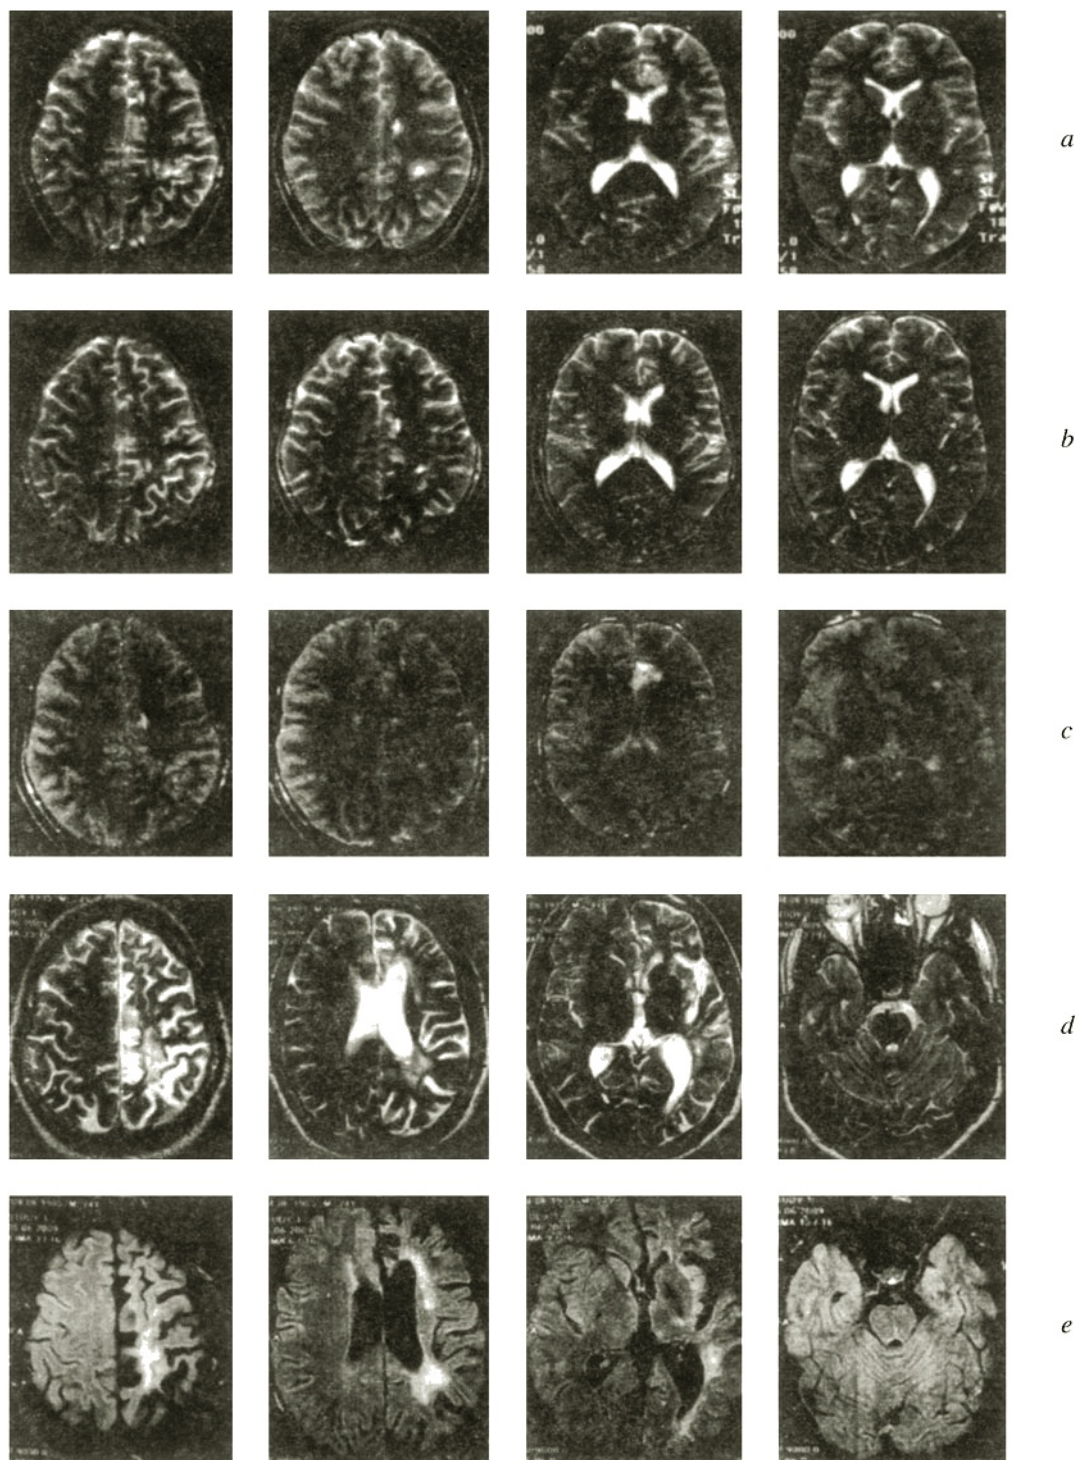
Rasmussen's encephalitis. Sequences of images in the axial projection at the supraventricular and ventricular levels (*a–e*). *a*) February 21, 2000 – foci of hyperintense signal of irregular shape in the subcortical white matter of the frontal and parietal lobes of the left hemisphere, some with perifocal edema (T2-weighted regime); *b*) May 7, 2001 – regression of perifocal edema and decreases in sizes of foci at the supraventricular level, along with the largest subcortical focus in the mediobasal parts of the left frontal lobe (T2-weighted regime); *c*) June 6, 2002 – deterioration, with appearance of new foci (in the left frontal lobe at the supraventricular level and in the anterior parts of the left insula), increases in the sizes of foci in the mediobasal parts of the left frontal lobe, propagating to the adjacent cortex and genu of the corpus callosum (PD); *d*) June 5, 2009 – extensive diffuse focal changes in the white matter of the left hemisphere and cortex of the left insula, marked atrophy of the left hemisphere (T2-weighted regime); *e*) June 5, 2009 – similar findings, FLAIR regime.
